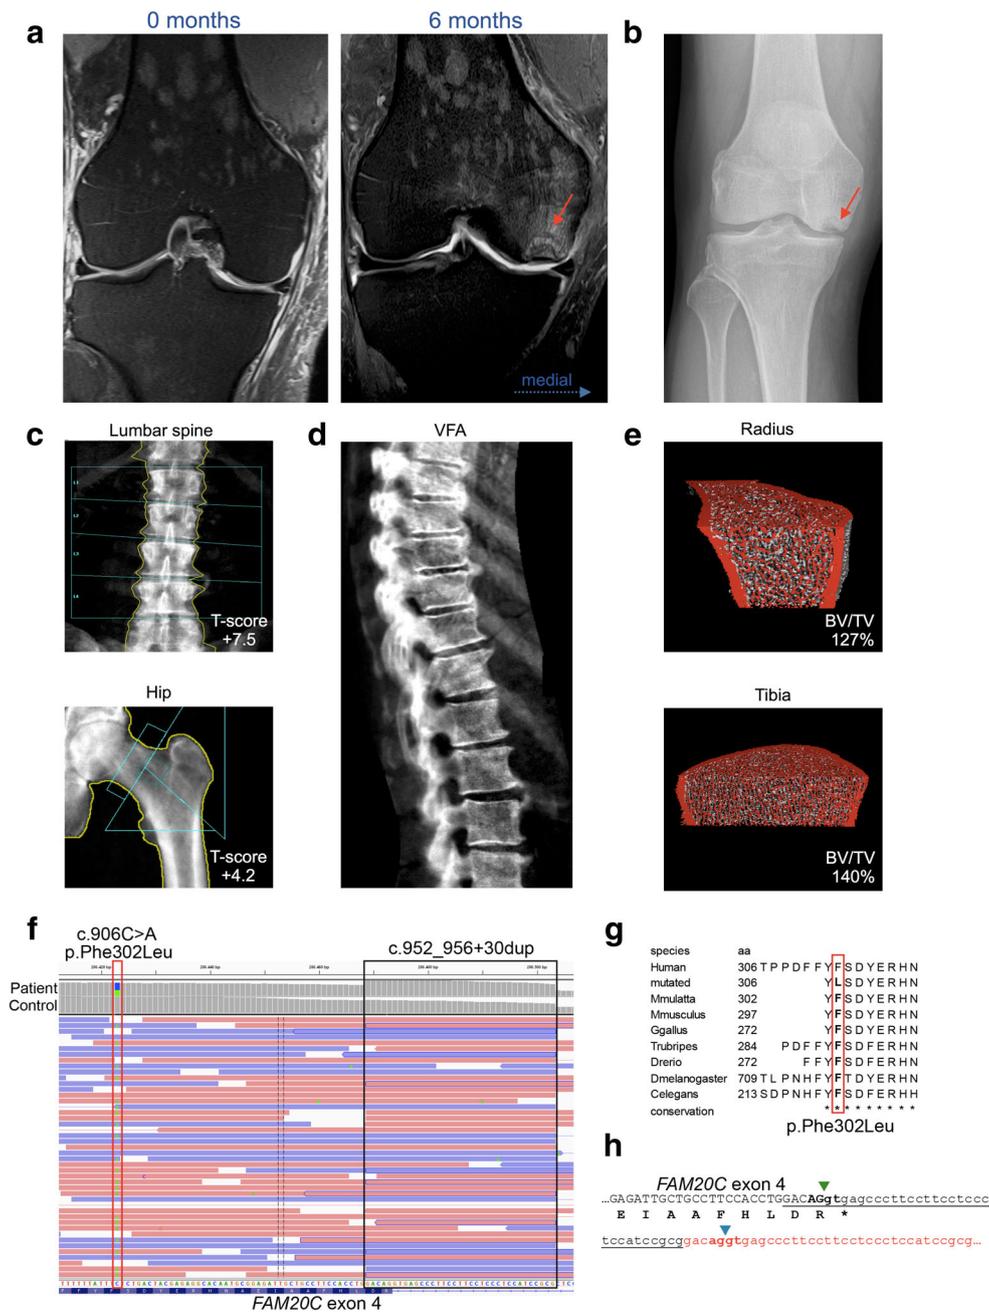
Spontaneous osteonecrosis of the knee in a patient with mild Raine syndrome. a MRI findings at initial presentation and after 6 months. Note the patchy bone marrow edema and the osteonecrosis in the medial condyle. Proton density (PD) weighted sequences at 6 months. b Anteroposterior radiography with the osteonecrosis area (red arrow) and unicondylar knee replacement. c Increased bone mass in detected by dual energy X-ray absorptiometry (DXA) in the spine and the hip. d No fractures or sandwich vertebrae (vertebral fracture assessment, VFA). e Bone microstructure analysis using HR-pQCT in the distal radius and tibia pointed to increased trabecular bone mass characterized by predominant increase in trabecular number. f–h Results of molecular genetic testing. f
